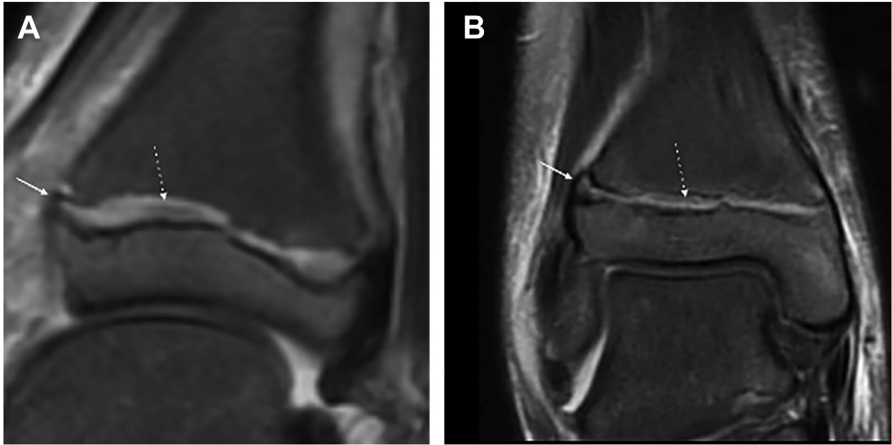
Salter-Harris I fracture and periosteal entrapment. Sagittal (A) and coronal (B) T2FS MRI of the ankle of a 10-year-old boy after an ankle sprain. Note the enlargement and loss of the trilaminar pattern of the distal physis of the tibia, compatible with Salter-Harris type I fracture (*dotted arrow*). There is also periosteal interposition on the anterolateral epiphyseal plate (*arrow*).
